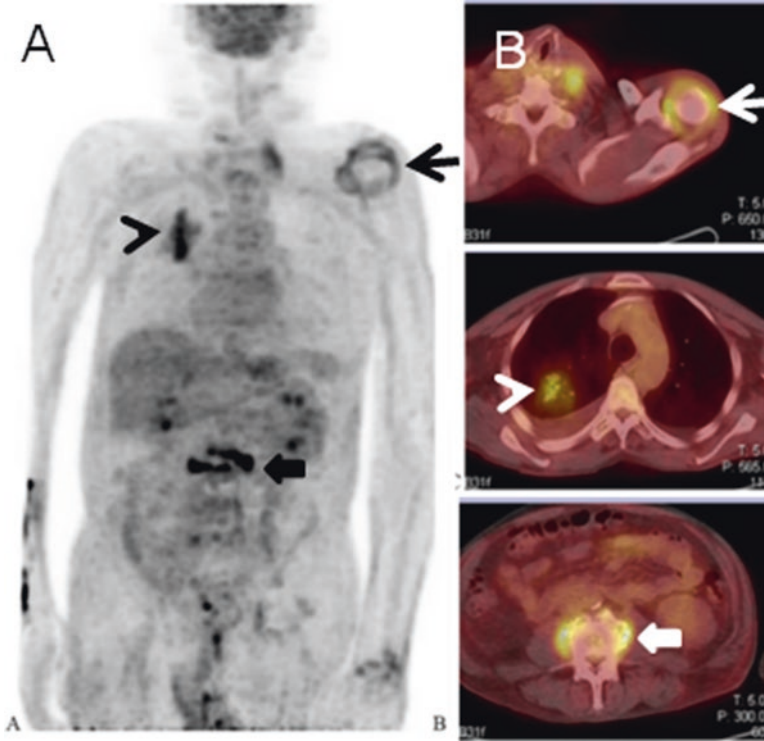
Multifocal infection in a patient with fever of unknown origin. 66-year-old man presented with altered mental status, intermittent fevers, and recent pneumococcal bacteremia. On the maximum-intensity-projection PET image (a) and axial PET/CT images (b), there are areas of increased ^{18}F -FDG uptake in the left shoulder (arrow), right upper lung (arrowhead), and mid lumbar spine (solid arrow), consistent with septic arthritis, pneumonia, and spondylodiscitis, respectively. Left shoulder and bronchial lavage cultures grew *Mycobacterium chelonae*
